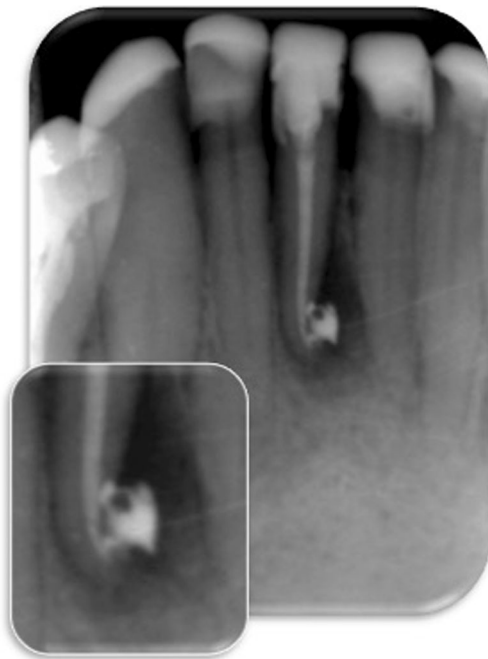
Case #1 final radiograph following the completion of the double-wavelength laser-assisted treatment. To be noticed is the apical delta completely debried and sealed
